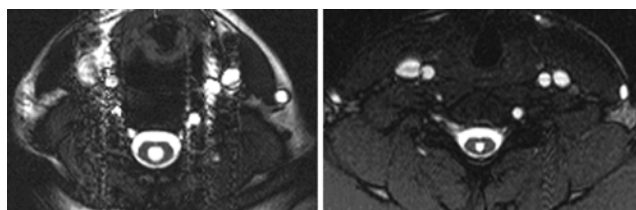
Representative initial (left) and 5-year follow-up (right) axial T2-weighted MR images demonstrating spontaneous regression in syrinx size over time.
